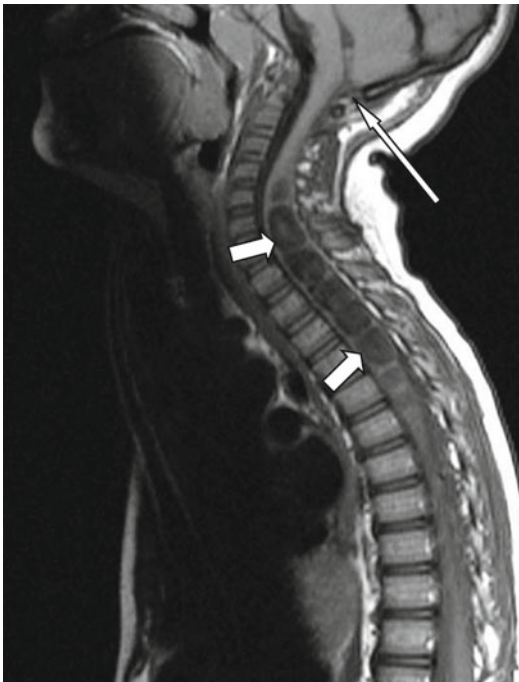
Sagittal T1-weighted MRI of the Chiari 0 malformation. Note the absence of cerebellar tonsillar herniation (*long arrow*) and large cervicothoracic syrinx (*short arrows*) that resolved following posterior fossa decompression
